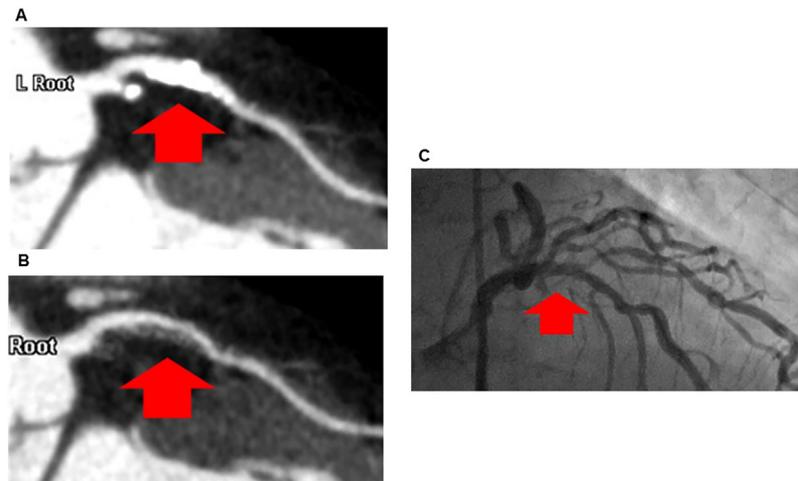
78-year-old female who underwent C-CCTA, S-CCTA, and ICA. Agatston score was 1409.6. DLP was 60.4 mGy cm (0.8456 mSv). (A) Curved MPR image of the LAD by using C-CCTA (arrow). (B) Curved MPR image of the LAD by using S-CCTA (arrow). (C) ICA of the LAD (arrow). C-CCTA, conventional coronary computed tomography angiography; S-CCTA, subtraction coronary computed tomography angiography; ICA, invasive coronary angiography; DLP, dose length product; MPR, multiplanar reformatting; LAD, left anterior descending artery.
